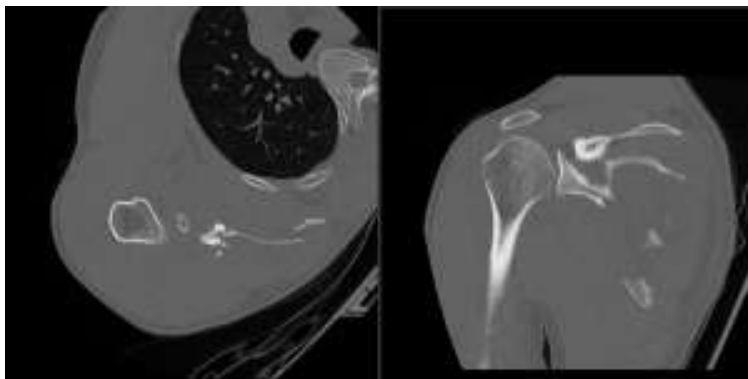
Axial and sagittal computed tomography (CT) images of same shoulder in Figure 4 showing an intact glenoid, but significant displacement and comminution of the fracture.
